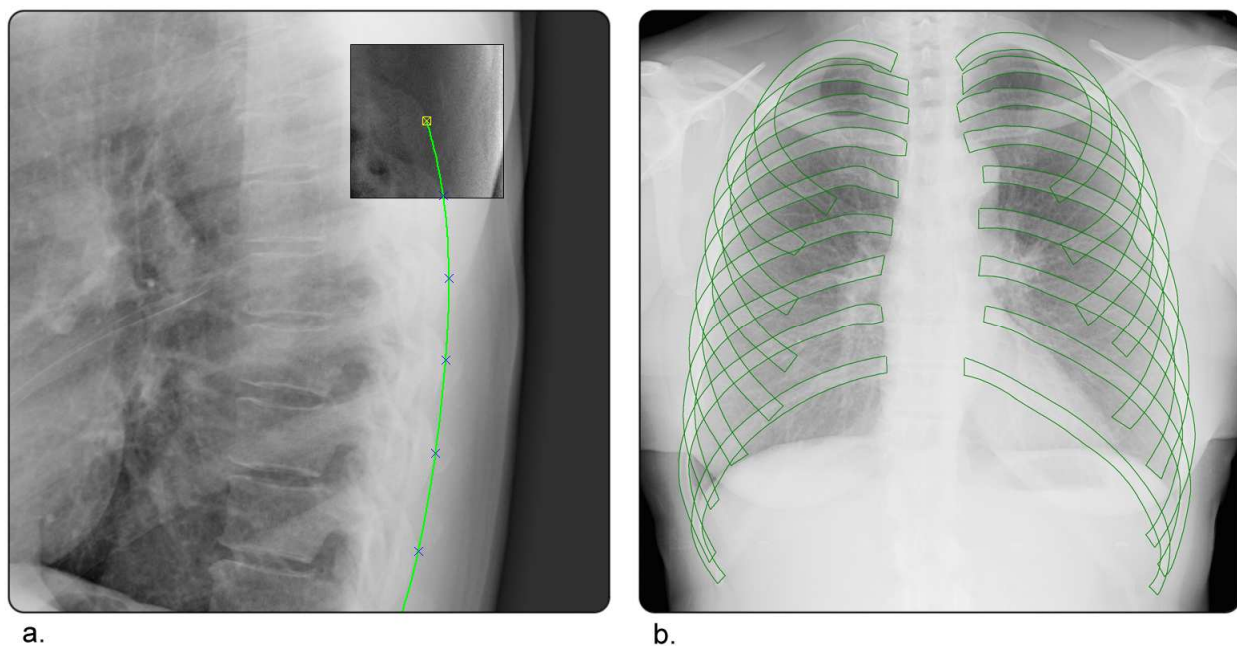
(a.) Interactive segmentation of the ribcage outer border. (b.) Segmented ribs in a PA X-ray image.
